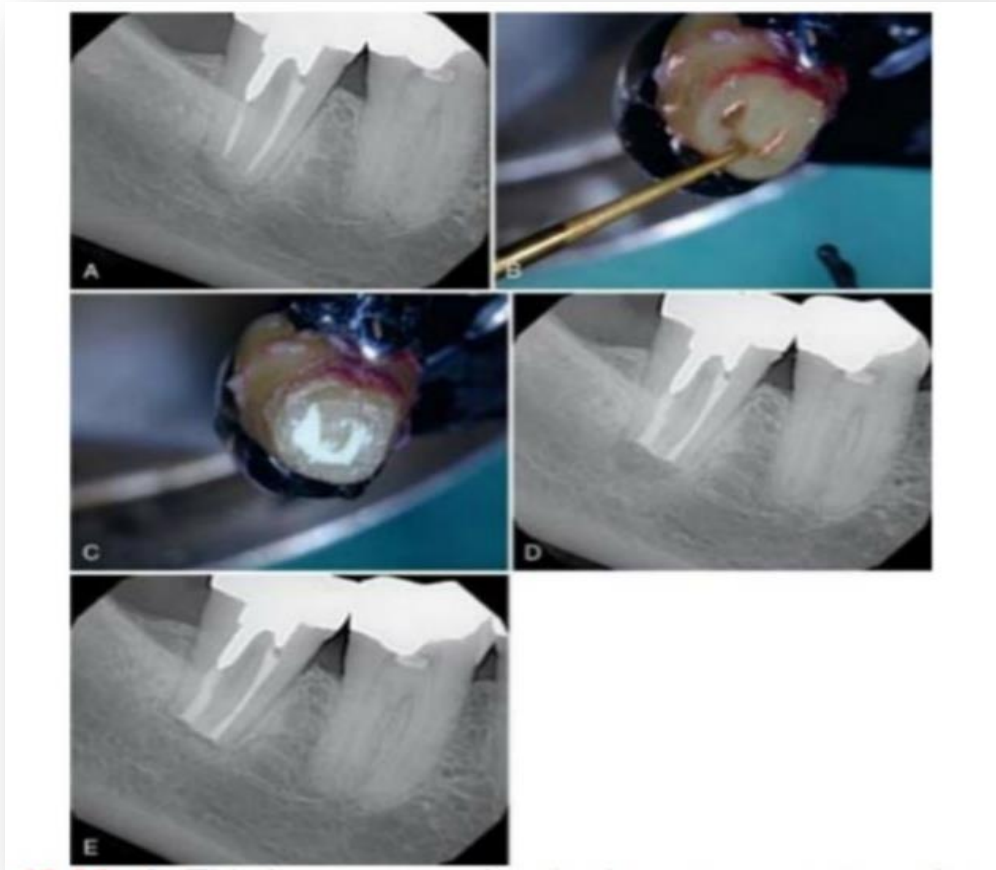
A-This lower second molar became symptomatic many years after nonsurgical treatment. Nonsurgical retreatment had a guarded prognosis due to the large multiroot cast custom post and core. Surgery was precluded by the poor access and proximity of the inferior alveolar canal. B-Ultrasonic root end preparation is made in the extracted tooth. C, A-white MTA retrograde filling was placed. Note the C-shape. D- Immediate post-implantation radiograph. E- Seven-month reevaluation showing apical healing. The patient was asymptomatic.
